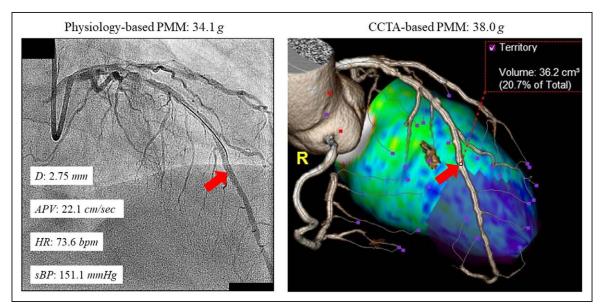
The assessment of physiology- and coronary computed tomography angiography (CCTA)-based partial myocardial mass (PMM). The Doppler flow sensing position was located at the mid left anterior descending coronary artery (red arrow) and mean vessel diameter, systolic blood pressure (sBP), heart rate (HR), and average peak blood flow velocity (APV) at the position were 2.75 mm, 151.1 mm Hg, 73.6 bpm, and 22.1 cm/s. As the result, physiology-based PMM was calculated as 34.1 g. On the contrary, CCTA-based PMM at the same position was 38.0 g. D indicates mean vessel diameter at the Doppler flow sensing position.
